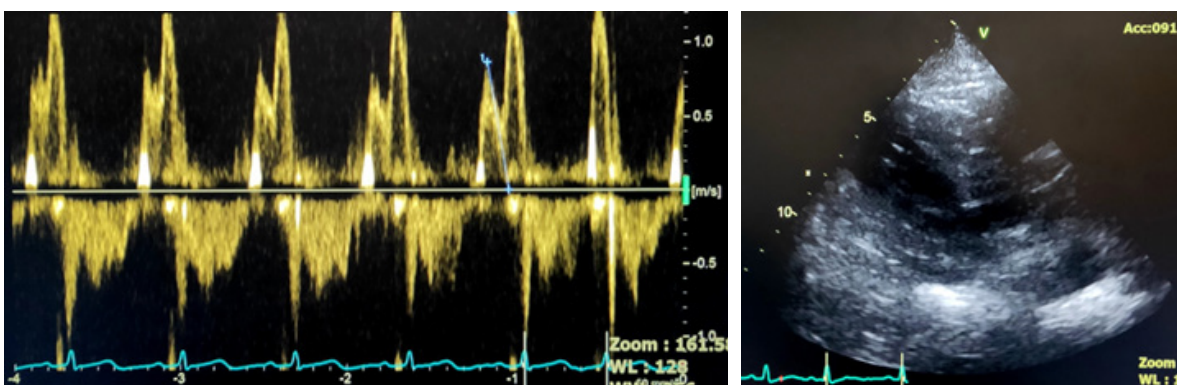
(A) Pulsed doppler echocardiography of the mitral inflow showing significant E-A wave de-fusion post treatment with ivabradine. (B) Pleural effusion resolved post treatment with ivabradine.
